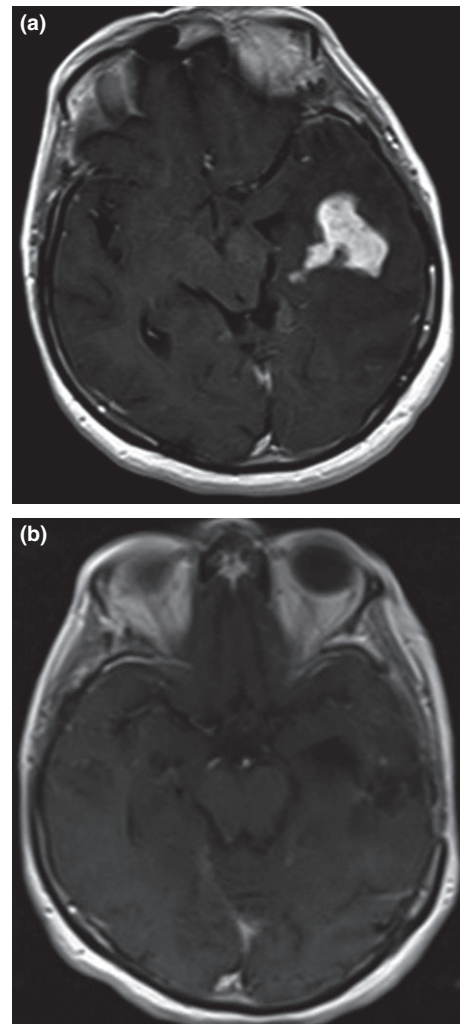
Pre-op (a) and post-op (b) axial MRI of the brain performed with contrast material.
